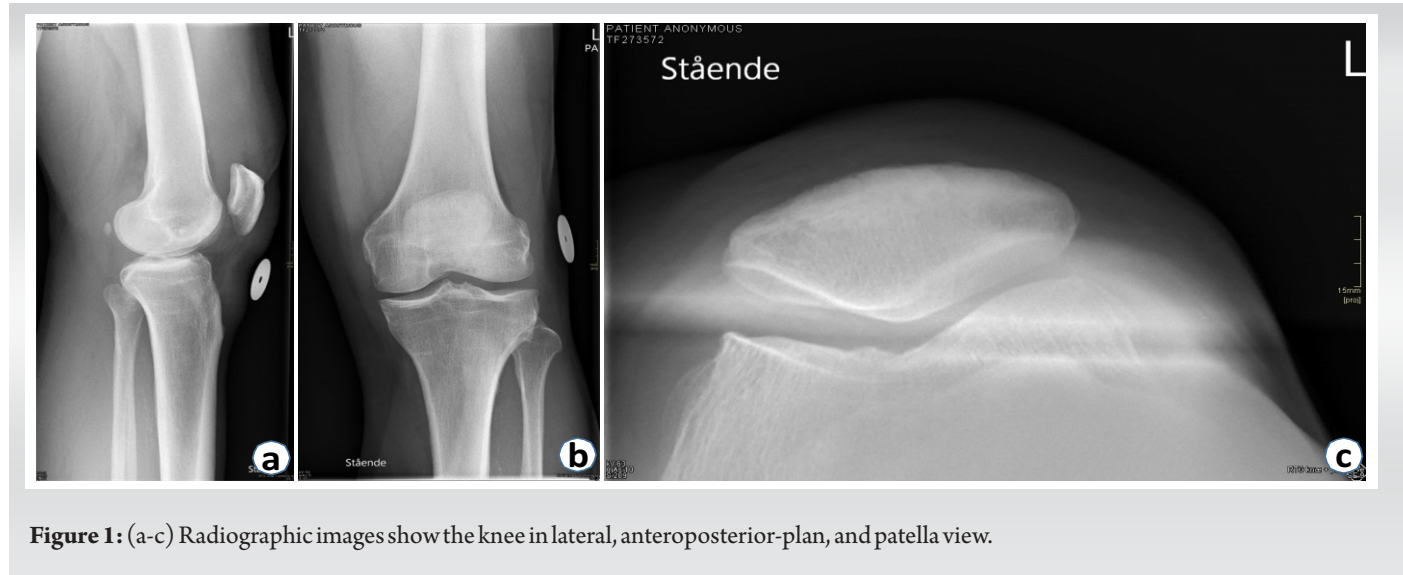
(a-c) Radiographic images show the knee in lateral, anteroposterior-plan, and patella view.
